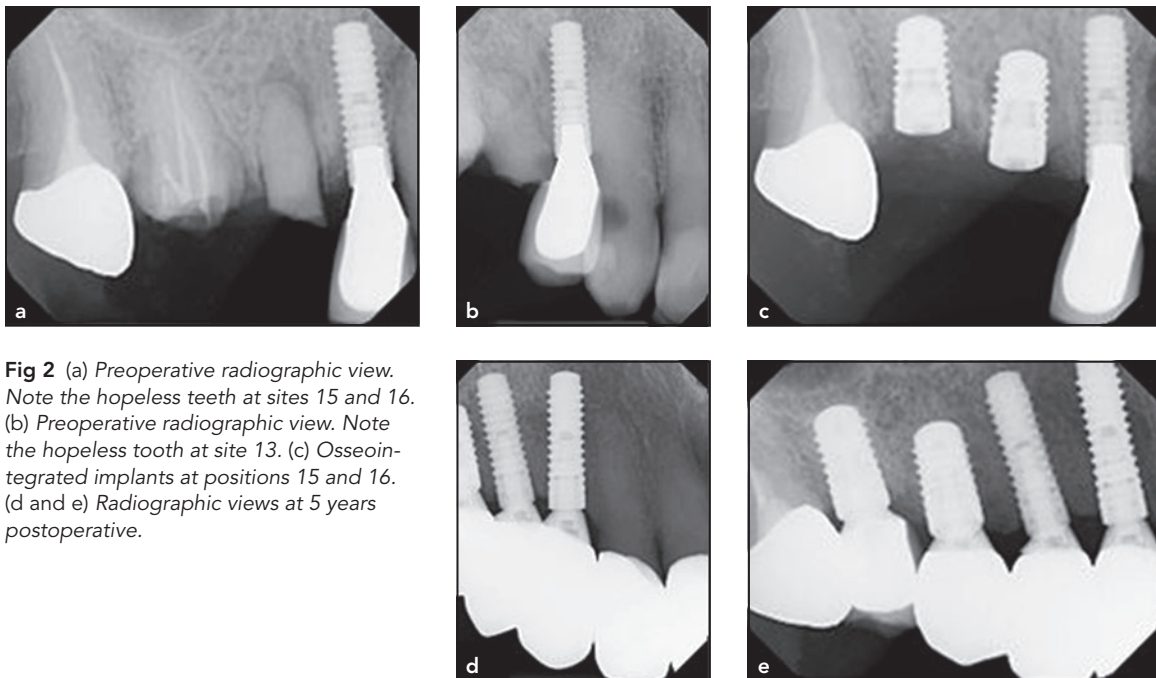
(a) Preoperative radiographic view. Note the hopeless teeth at sites 15 and 16. (b) Preoperative radiographic view. Note the hopeless tooth at site 13. (c) Osseointegrated implants at positions 15 and 16. (d and e) Radiographic views at 5 years postoperative.
